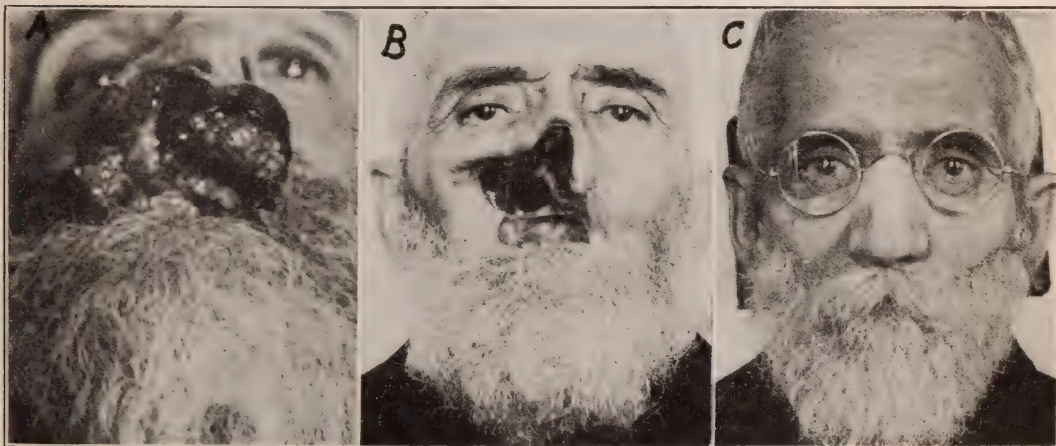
A, epithelioma involving upper lip, antrum, septum, nose, alveolus and hard palate, of three years' duration, in a man, aged 66, referred by Dr. J. D. Graber, of Royersford, Pa. Previous treatment by plasters and the roentgen ray had been unsuccessful. The case was pronounced hopeless from a surgical standpoint by Dr. John Chalmers DaCosta, of Philadelphia. One electrothermic coagulation treatment under ether anesthesia was given, March 1, 1916, and two slight recurrences were treated under local anesthesia by the desiccation method. B, final result, with no recurrence in two years and five months. C, reconstructed features by the sculpture method, executed by Major R. Tait McKenzie, of Philadelphia, and Mrs. Alan Chesney, of Baltimore. A plaster cast was made and the lost features built out in clay. A copper plate of suitable thickness was deposited on the cast by electrolysis and then silver plated. This plate was painted to match the tint of the skin, the mustache added and the plate attached to the rims of the glasses. A similar plate may be kept in place by means of spirit gum without the aid of the glass frames if desired. A plate is under construction to replace the hard palate and with artificial upper and lower teeth, in the hope that the patient may improve articulation and better masticate his food.
